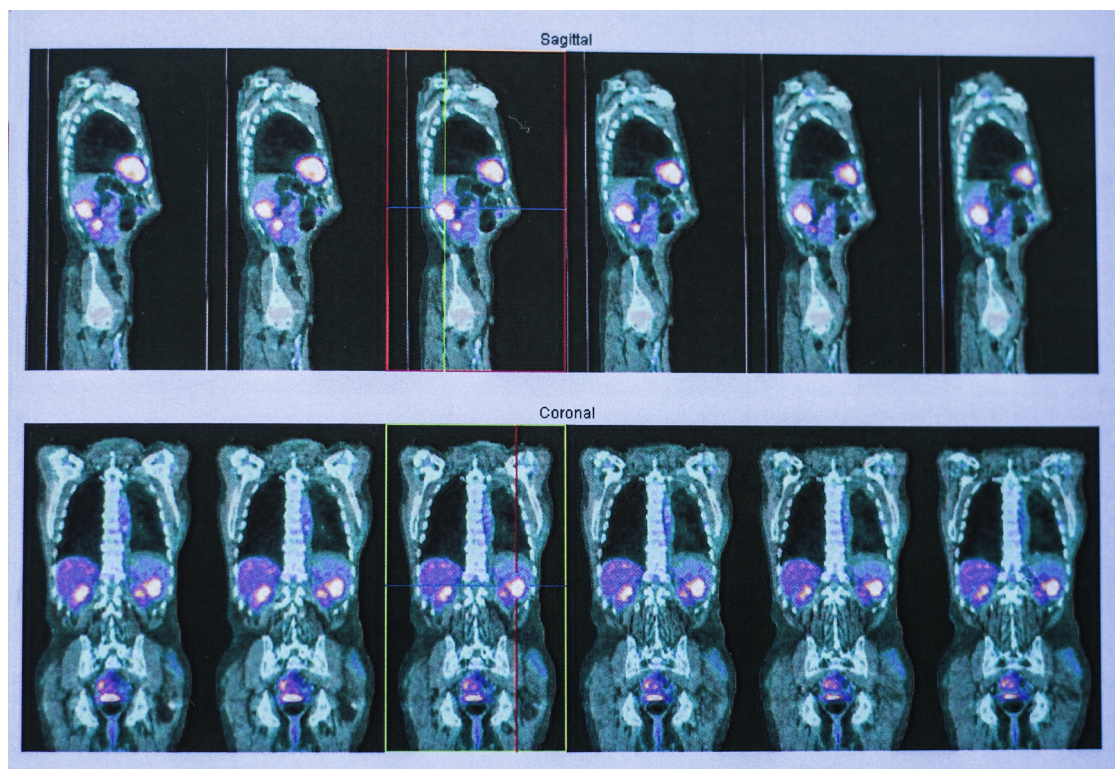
Image of PET-CT showing a splenic hot spot, suspect of metastasis.
